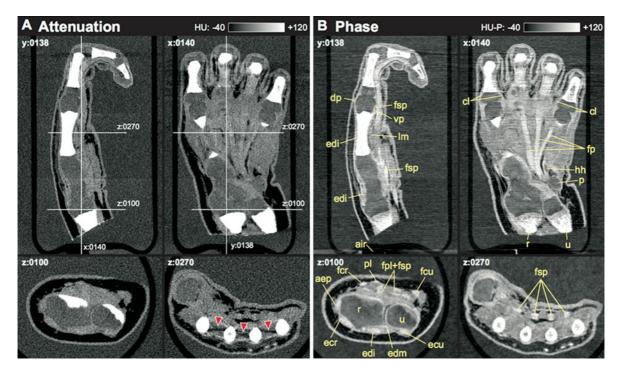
Initial imaging experience in human tissue using phase-contrast CT (from: Donath et al. 2010)
